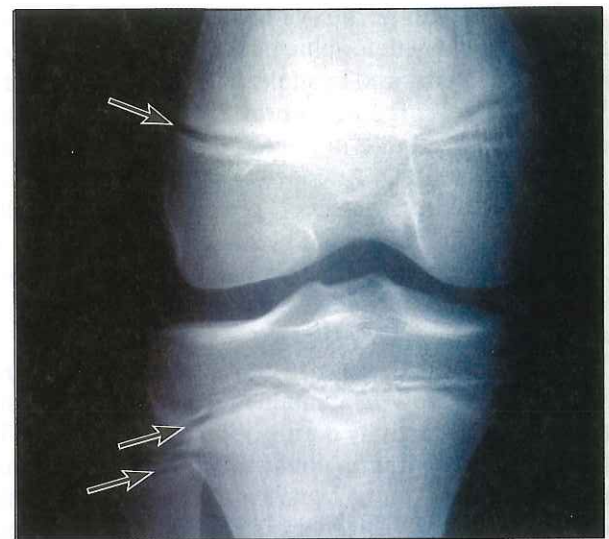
Radiograph showing epiphyseal plates (arrows) in a child's bones indicates that the bones are still lengthening.
